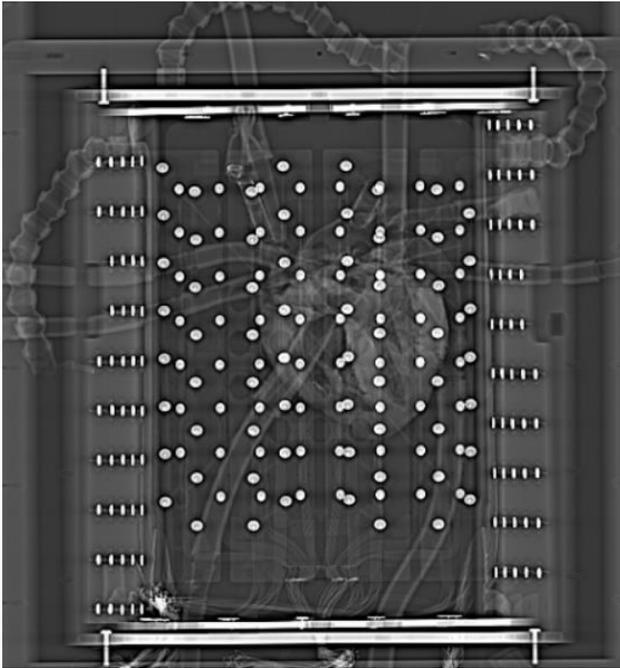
A CT scan of a previously reanimated human heart positioned in the epicardial mapping tank with all 252 electrodes.
